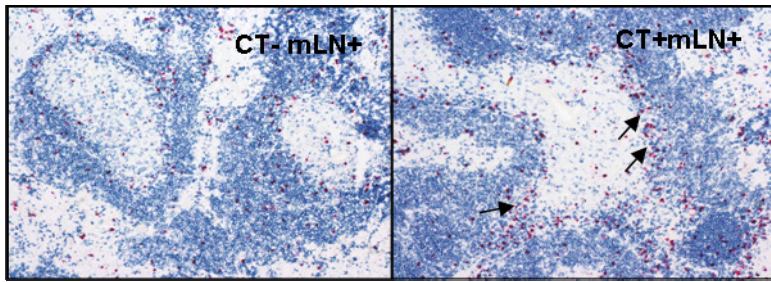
The resection of the mLN has no affect on CT-specific IgA⁺ B cells in secondary lymphoid organs.
